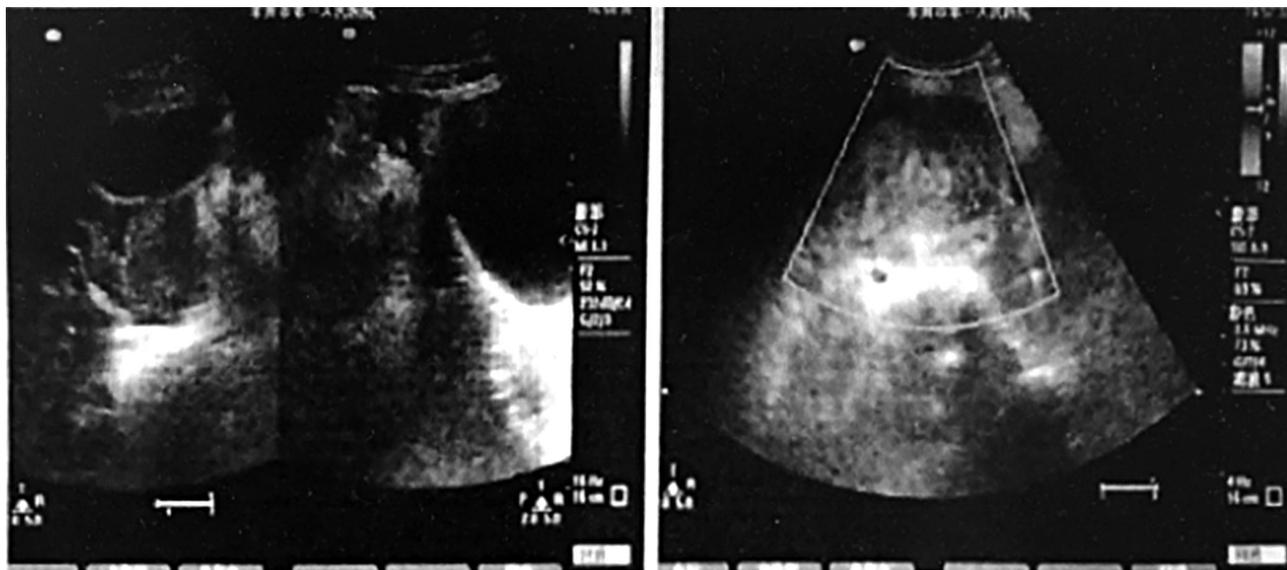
Ultrasound views of the first surgery.
